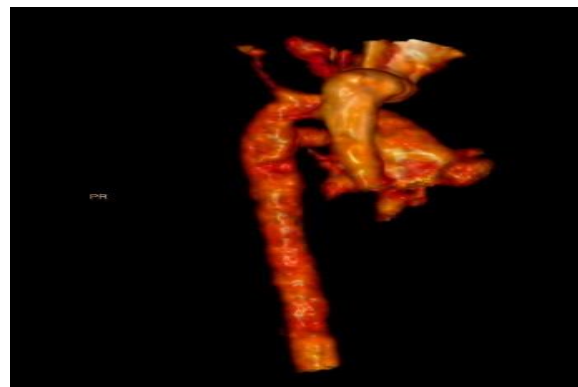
CT angiogram of clear visualisation of double-sided aortic arch.
